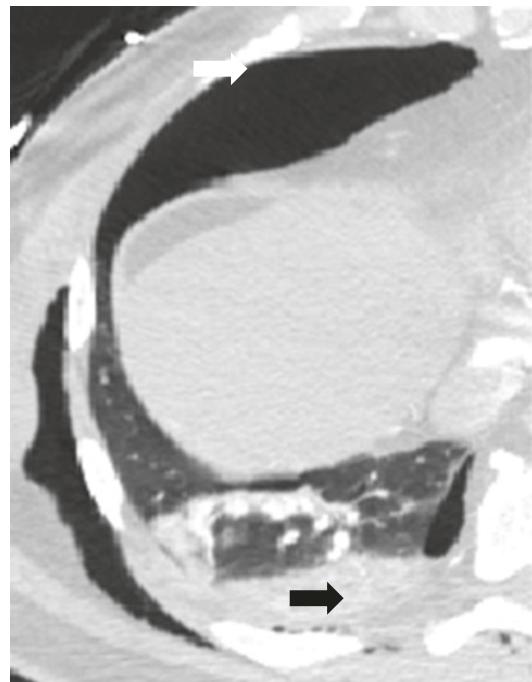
Sixty two-year-old man presenting after MVC. Axial IV contrast-enhanced CT image of the right lung shows pneumothorax (white arrow) and hemothorax (black arrow)
